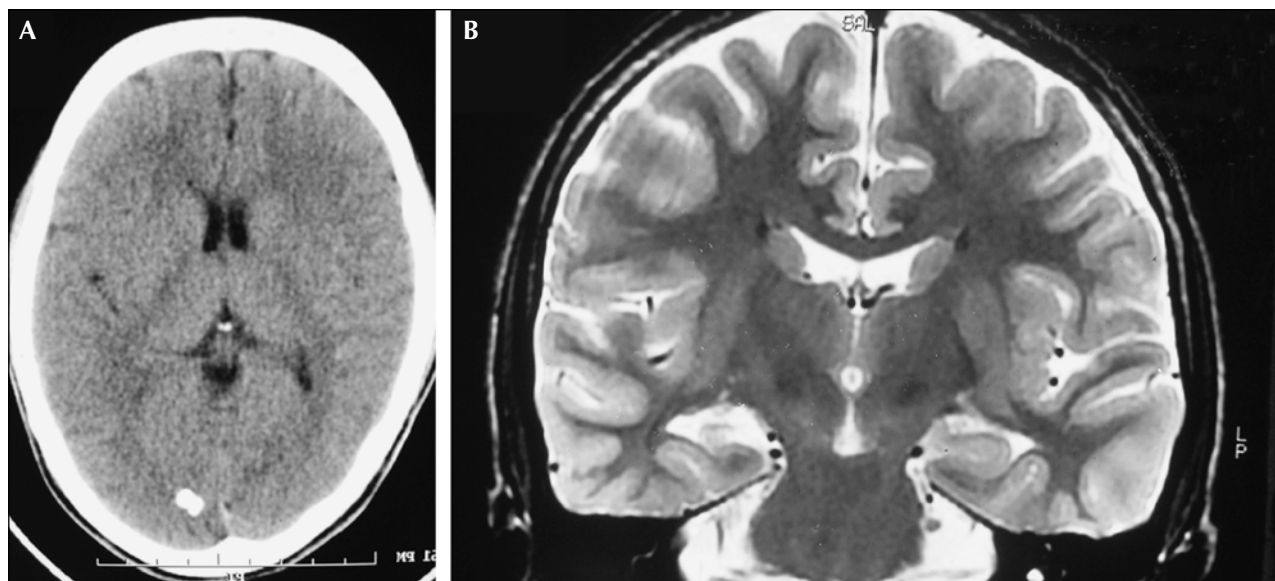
Case 4. A) Initial CT revealed the right occipital calcification, possibly a sequela of earlier cysticercus granuloma. B) Coronal oblique FLAIR image performed several years later showing the dilated right temporal horn with hippocampal hyperintensity.
